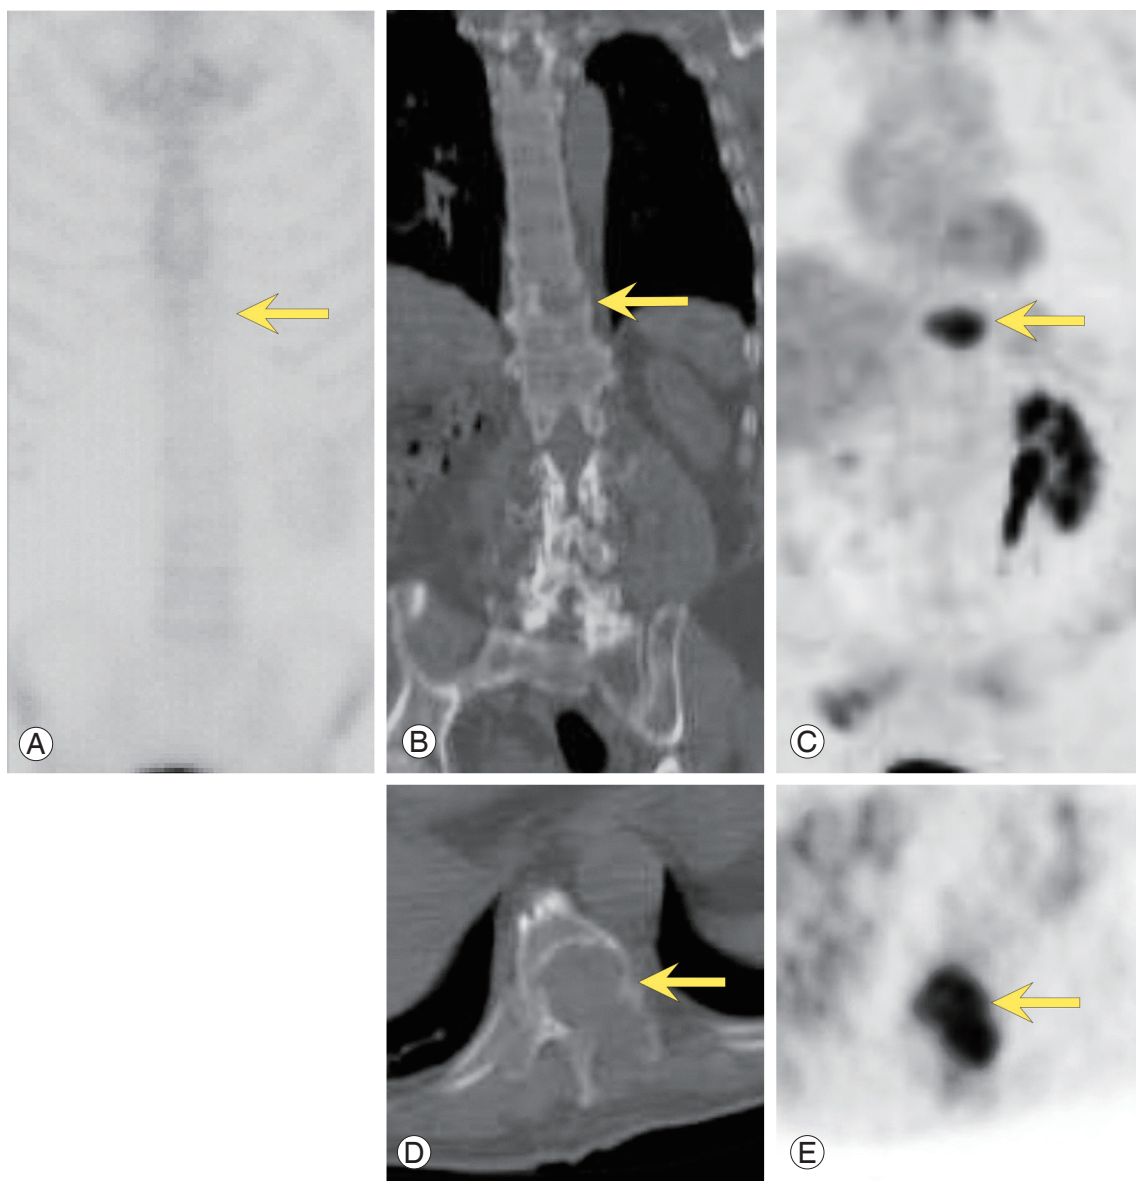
Bone scan (A), computed tomography (CT) (B, D) and fluorodeoxyglucose (FDG) positron emission tomography (PET) (C, E) images of a 69-year-old man with renal cell carcinoma. Note the focal intense uptake in osteolytic spine metastases (vertebral body of T10) on PET only but not on the bone scan (arrows). Axial and coronal CT images show osteolytic changes in the vertebral body (B, D) and focal intense uptake on the PET images (C, E).
